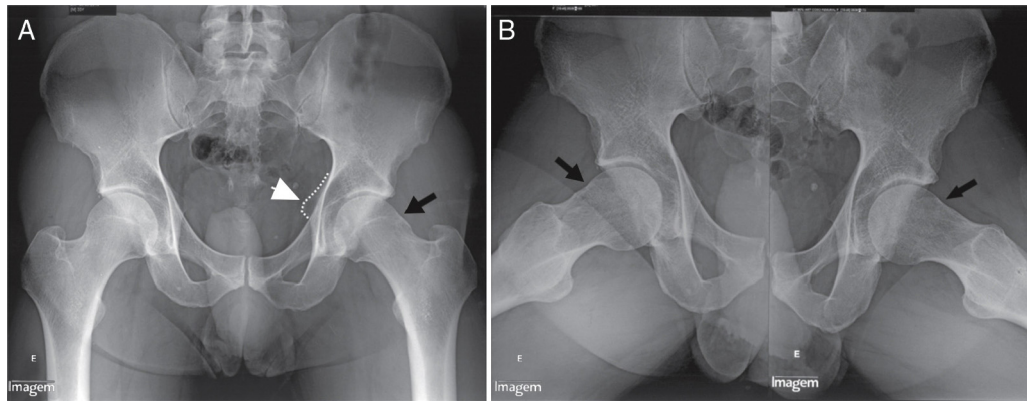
Alterations on hip X-rays in cases of femoroacetabular impact. (A) In the proximal region of the left femur, there is a typical pistol grip deformity, with rectification of the sphericity of the anterior portion of the femoral head (black arrow). In this radiograph there is a greater prominence of the ischial spine, which suggests an associated acetabular retroversion (white arrowhead). (B) The same patient on the Lauenstein view; this radiograph shows the decrease in the head-neck offset on both sides, with alterations that predispose to impingement (black arrows).
